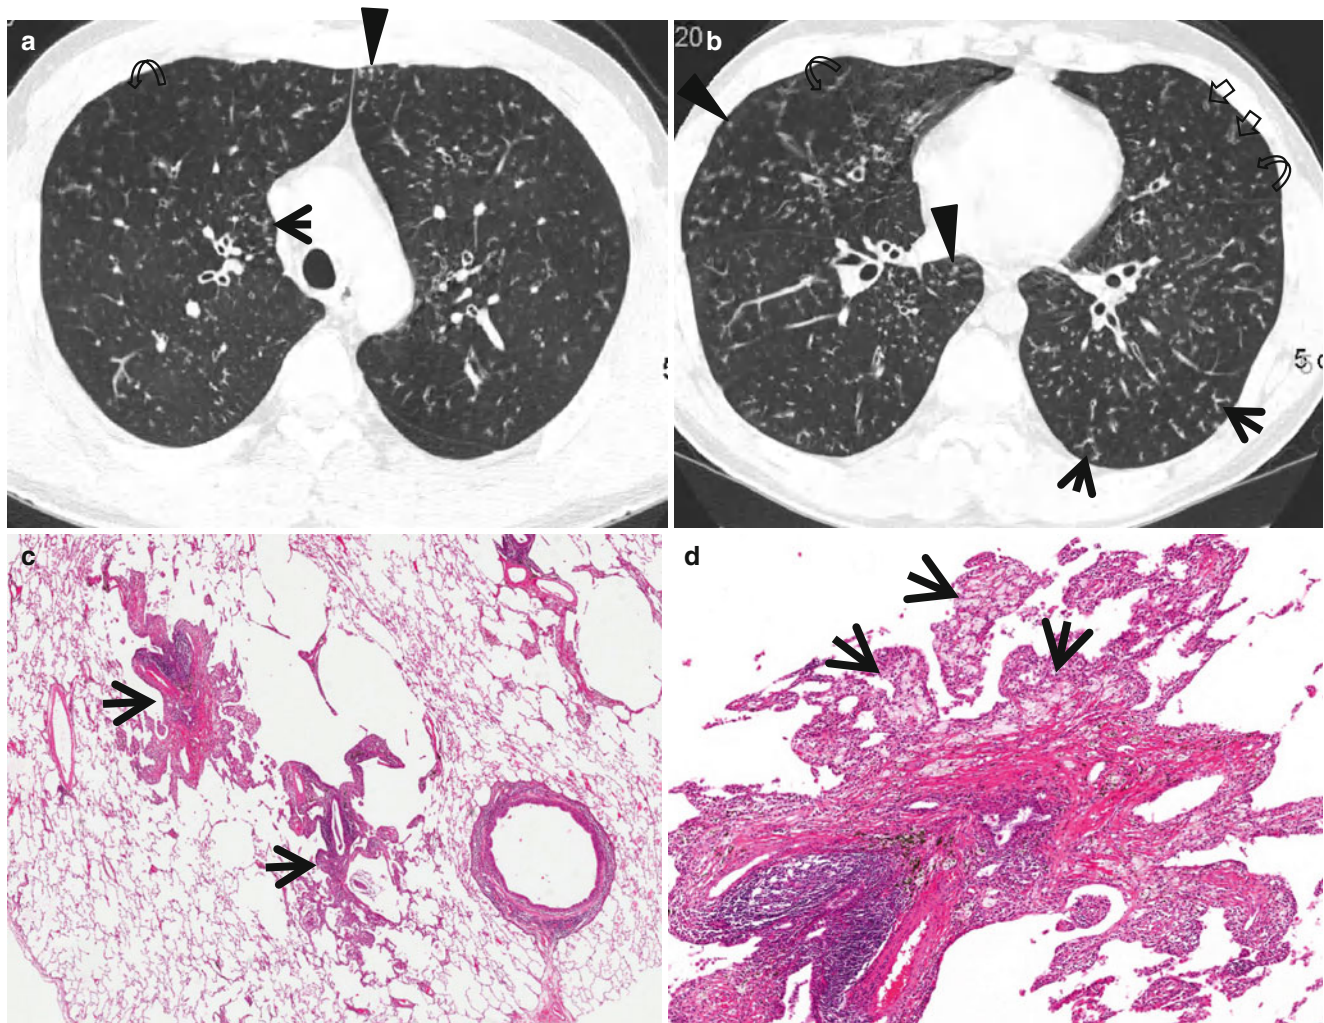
Diffuse panbronchiolitis in a 38-year-old man. (a, b) Lung window images of thin-section CT scans (1.5-mm section thickness) obtained at levels of aortic arch (a) and right inferior pulmonary vein (b), respectively, show small centrilobular nodules (arrowheads), tree-in-bud signs (arrows), bronchiolectasis (open arrows), and area of mosaic attenuation (curved arrows) in both lungs. (c) Low-magnification (x40)
